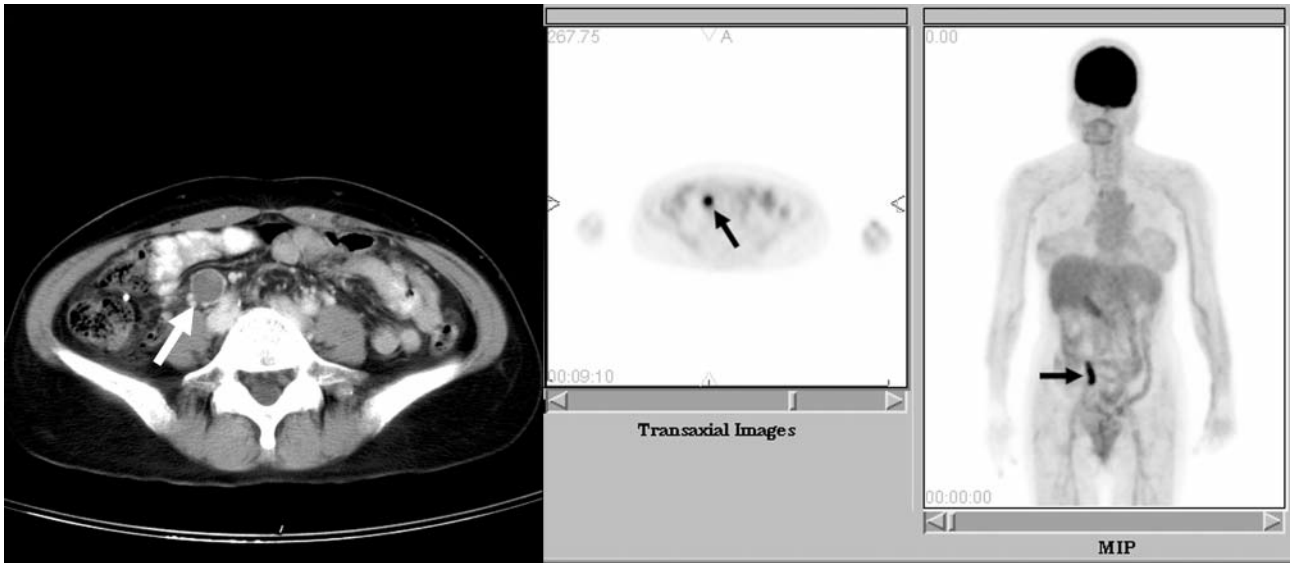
Right middle third ureteral TCC of patient no. 4 arrowed in the transaxial slice of CT, transaxial slice of FDG PET and the maximum intensity projection (MIP) image of FDG PET. Notice in the MIP image that there is no excretory urinary FDG radioactivity in the urinary system.
